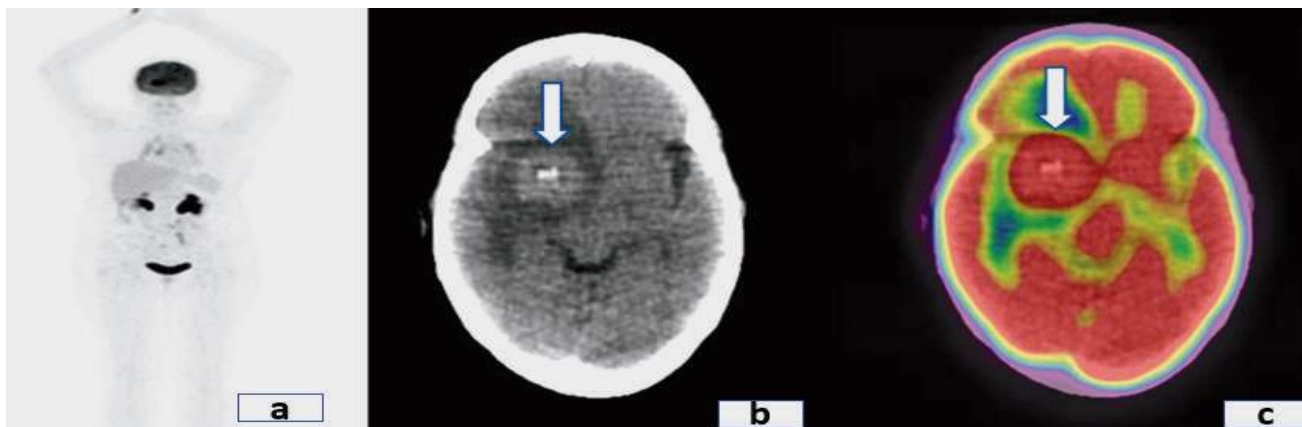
A 42-year-old male with CNS glioma. The MIP image (a) and fused PET-CT image (c) show a focal FDG-avid mass in the right occipital lobe, with a maximum SUV of 25.7 (white arrow). The corresponding axial CT image (b) demonstrates a hyperdense lesion with surrounding perilesional hypodense edema (white arrow).
